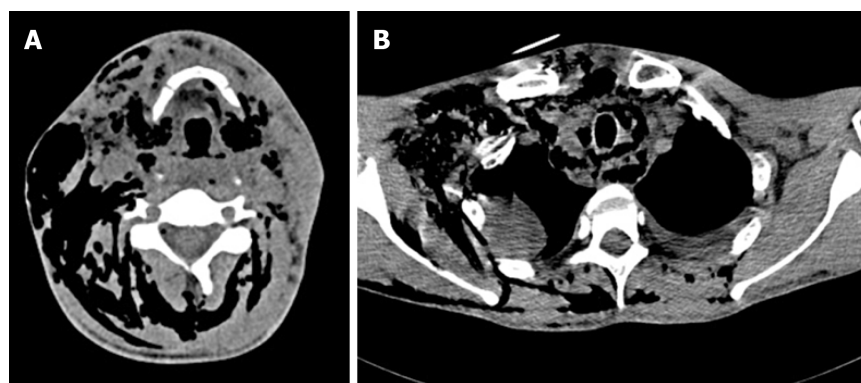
Transverse computed tomography scan of the hyoid plane and mediastinal plane. A: Transverse computed tomography (CT) scan of the hyoid plane showing extensive swelling and pneumatosis in soft tissues of the bilateral cervical region, parapharyngeal space, paracervical spine and posterior cervical region, especially in the right neck; B: Transverse CT scan of the mediastinal plane showing extensive pneumatosis in the mediastinal region.
